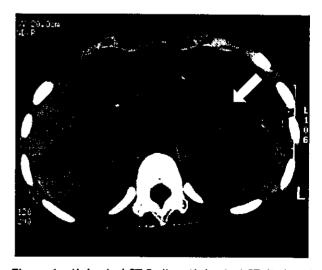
Abdominal CT finding. Abdominal CT disclosed diffuse markedly swelling of pancreas.
